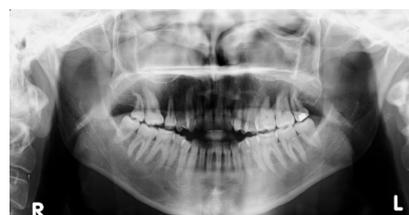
Orthopantomogram (OPG) at the beginning of treatment
